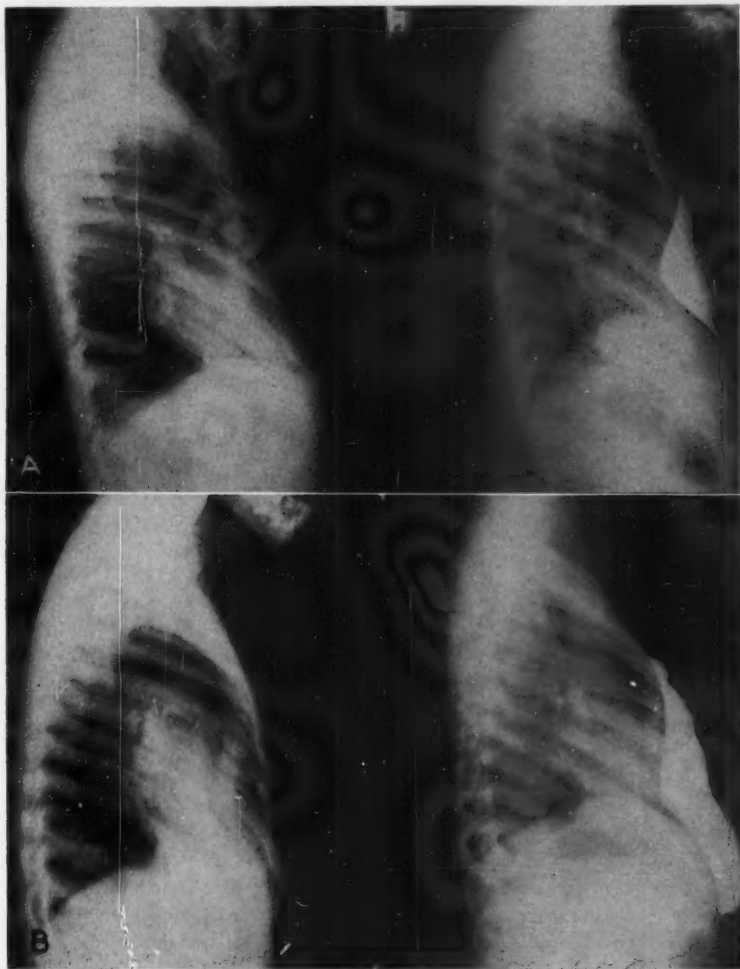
(A) The lateral roentgenogram of the chest on the left is that of a four-year-old boy. The roentgenogram on the right is of a two and one-half-year-old girl. Both demonstrate the greatest posterior displacement of the sternum to be several centimeters above the diaphragmatic attachment. (B) Both lateral roentgenograms are of the same six-year-old white girl. The left is exposed during inspiration the right during expiration. The inspiratory roentgenogram shows the greatest depression of the sternum well above the diaphragmatic attachment.
